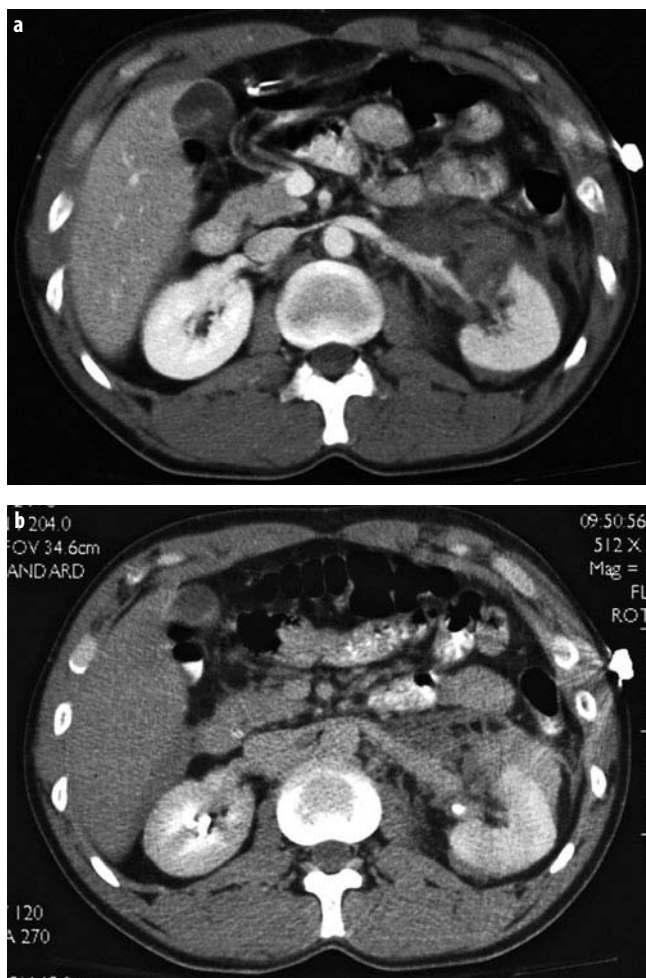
a, b. Hematuria after fall from a power line. a Initial CT shows left renal laceration with perinephric hematoma. b Delay image shows no leak from the collecting system
